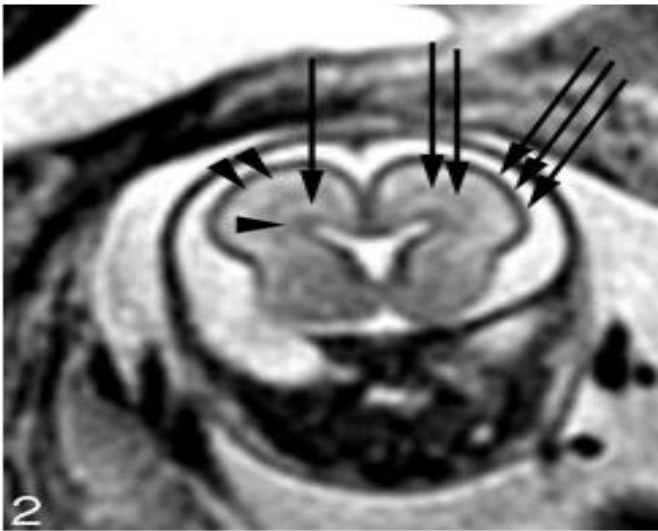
Coronal SS-FSE T2-weighted image at gestational week 23. Germinal matrix (arrowhead) periventricular zone (arrow). Subventricular and intermediate zones (double arrows). Subplate (double arrowheads). Germinal matrix (triple arrows)⁽¹⁵⁾.
